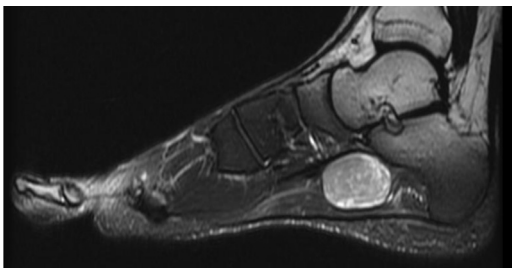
MRI Coronal view showing the tumour.
